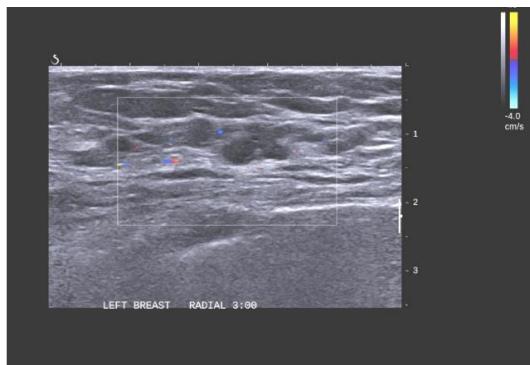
Targeted ultrasound corresponding to the mammogram finding in Figure 1 is a complex tubular mass, consistent with a complex ectatic duct.
